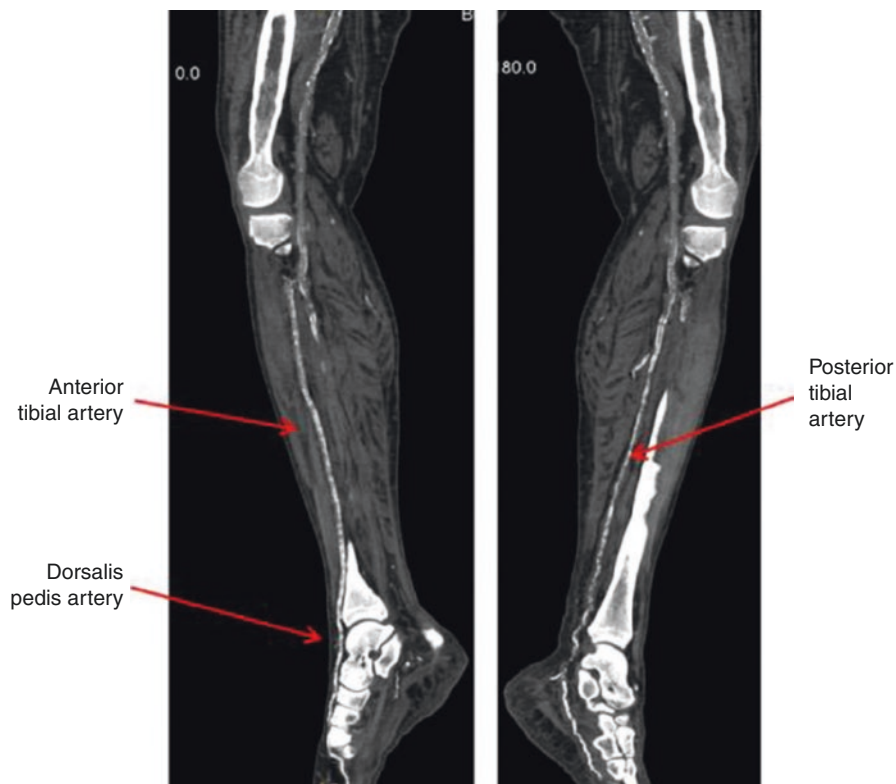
Computed tomography scans with calcified tibial arteries
